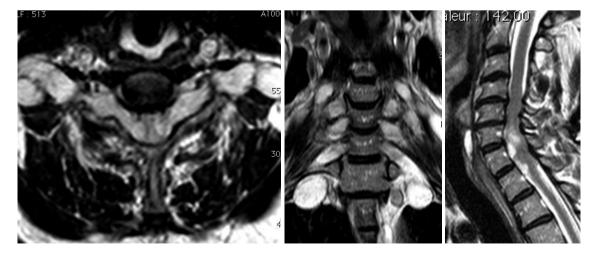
Preoperative magnetic resonance imaging: multiple level radicular hypertrophy with C5-7 myelopathy signs.
